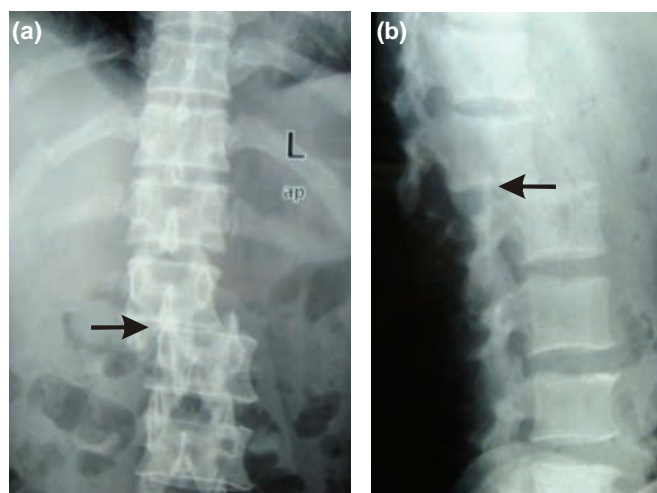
Fracture-dislocation of lumbar spine at L1–L2 level as seen in plain radiograph: (a) anteroposterior view, and (b) lateral view
